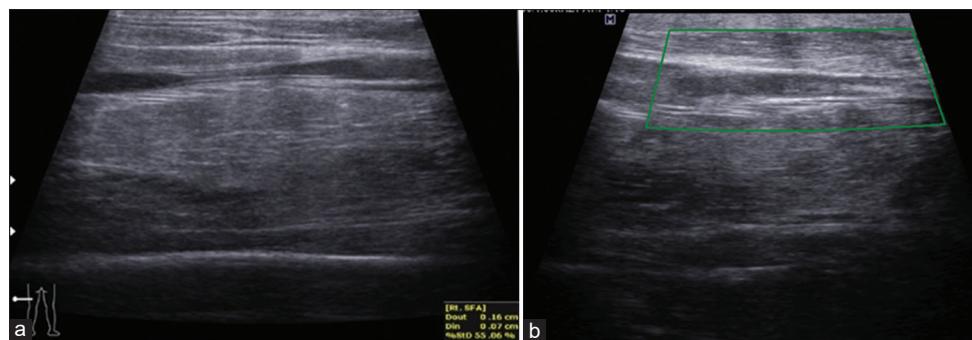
(a and b) The two images show atheromatous plaque in SFA causing nearly 55% luminal occlusion with no color filling seen on color Doppler interrogation. Findings likely represent chronic thrombosis of SFA.
